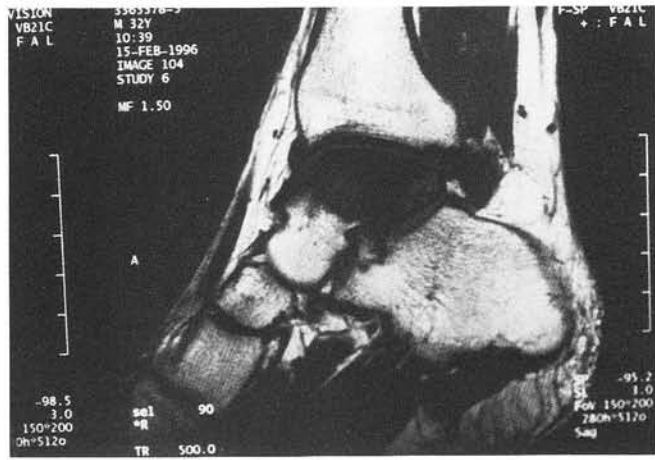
Sagittal T-1 MRI image. Note the avascularity of the talar dome on the images.
